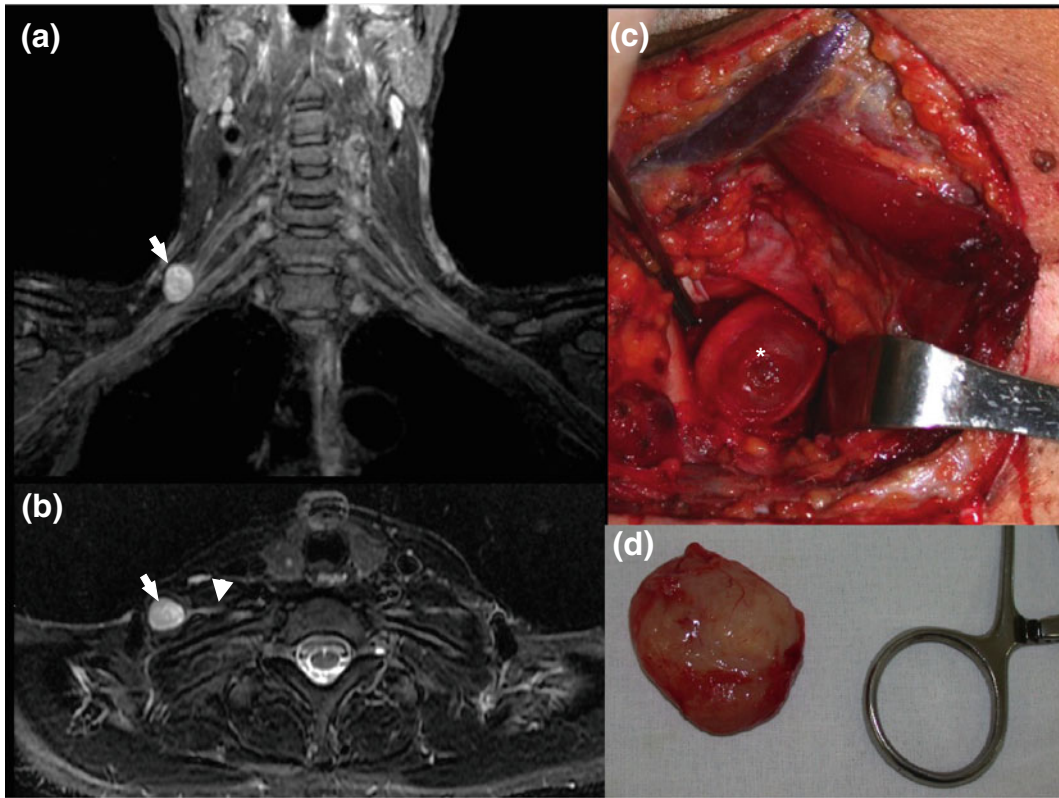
Schwannoma: brachial MRN in 38 year old woman with a palpable mass in the *right* supraclavicular space and, paresthesias and pain in the hand. Sequence 3D IDEAL coronal FAT SAT T2-weighted image (a), and 3D IDEAL axial T2-weighted image (b), shows a
